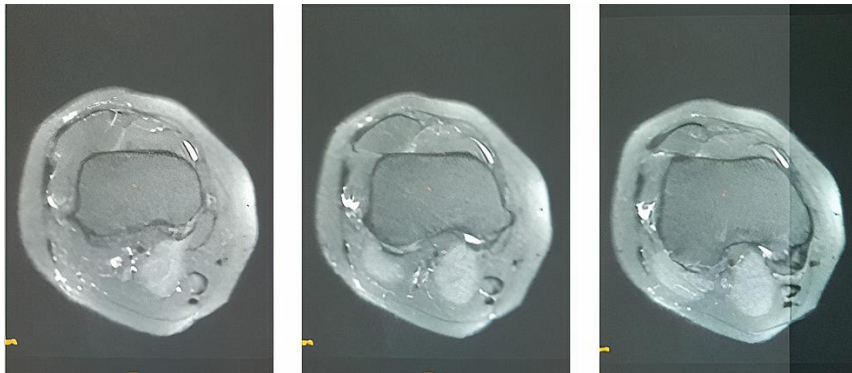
MRI of the knee showing flat surface appearance of lateral femoral condyle and lateral subluxation of the patella
